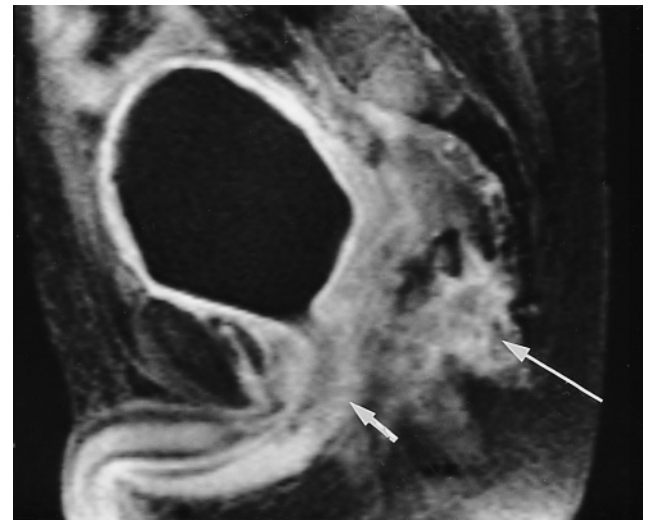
Invasion of prostate and membranous urethra by recurrent rectal carcinoma. Sagittal 90-s post-contrast fat-suppressed T1-weighted gradient-echo image. Heterogeneously enhancing recurrent rectal carcinoma is seen in the presacral space (long arrow). There is invasion of the prostate and membranous urethra (short arrow). Note the increased enhancement of the bladder wall secondary to radiation changes.
